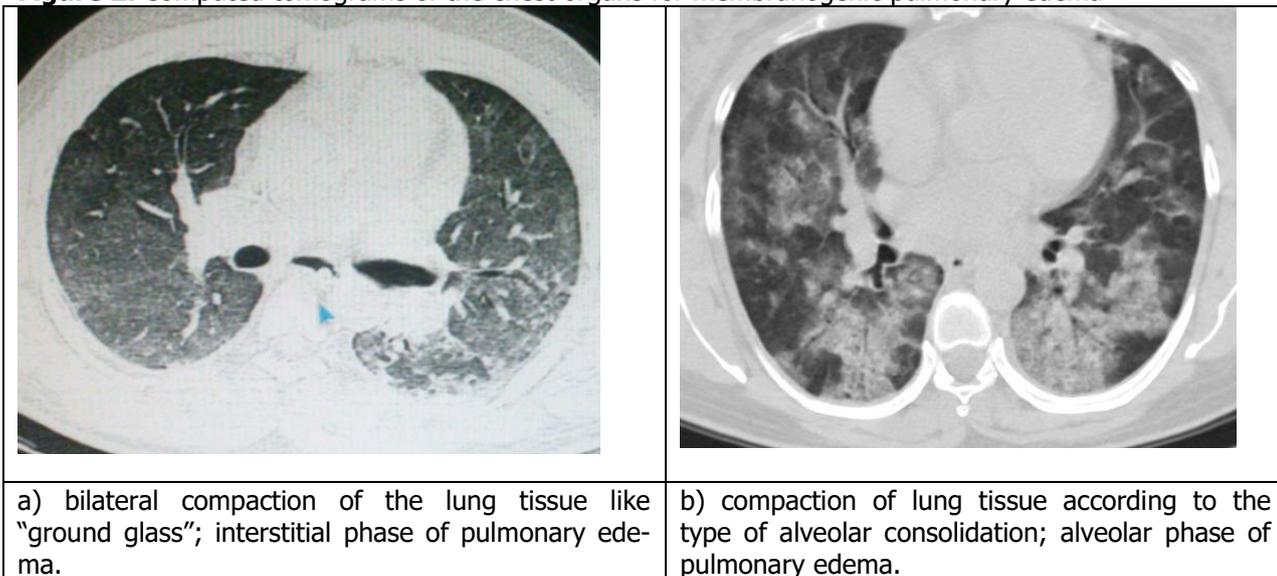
Computed tomograms of the chest organs for membranogenic pulmonary edema
